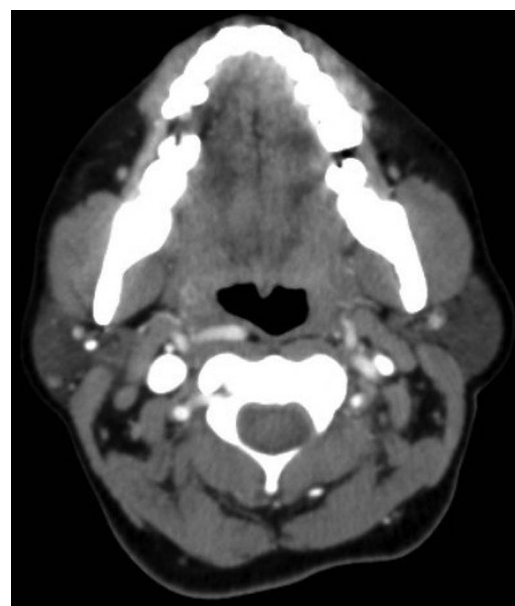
Axial contrast-enhanced CT of the neck showing aberrant internal carotid artery in proximity to the oropharyngeal wall with 3 mm of interspersed soft tissue.
